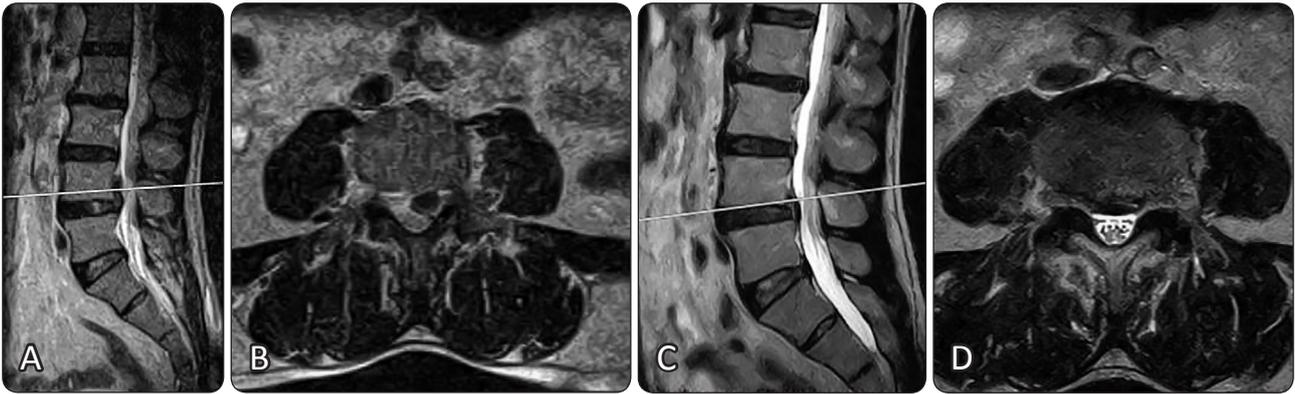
(A,B) Sagittal and axial T2WI MRI of the lumbar spine images show extruded disc fragment on the left side at the L4-5 level with upward migration. (C,D) Sagittal and axial T2WI MRI after 14 months showed regression of the extruded disc fragment at the L4-5 level.
